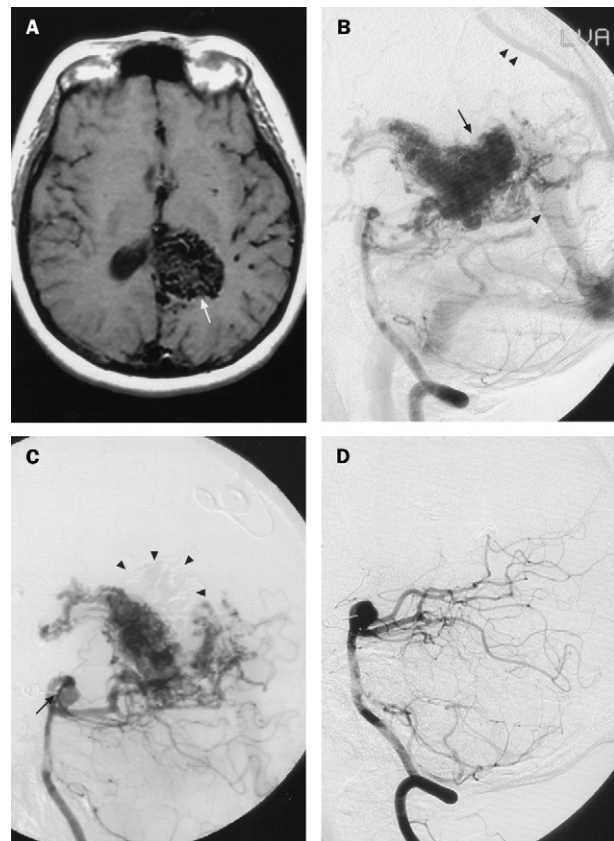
MRI scan (A) and diagnostic angiograms (B-D) of a 36-year old right-handed woman
